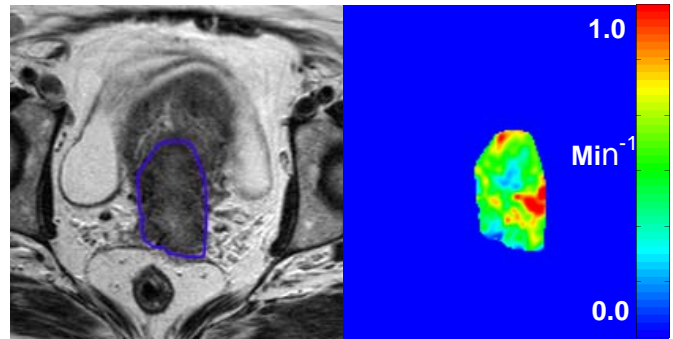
left: T2-weighted MRI of a cervix tumor (blue line) pre-treatment. right: K^{trans} map of the tumor, showing substantial heterogeneity in tissue perfusion.
